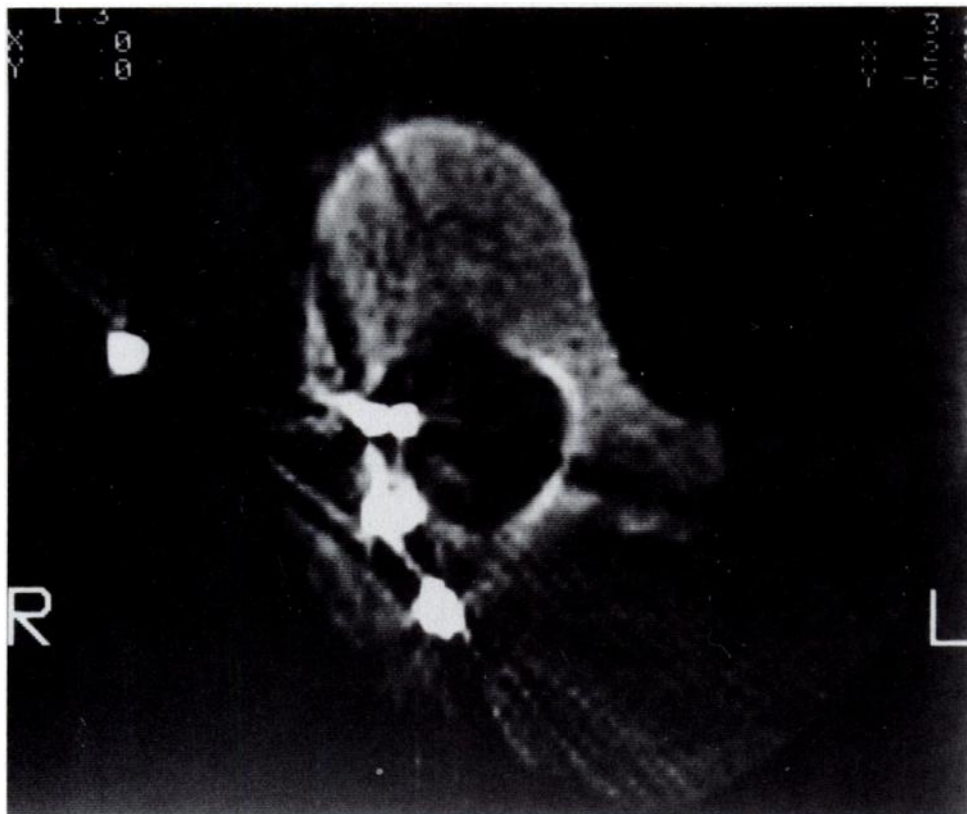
Computed tomographic scan reveals metallic fragments (birdshot) in spinal canal.
